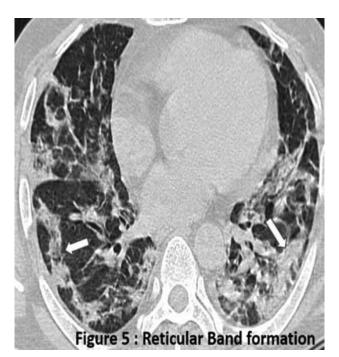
HRCT Axial image showing reticular band formation
